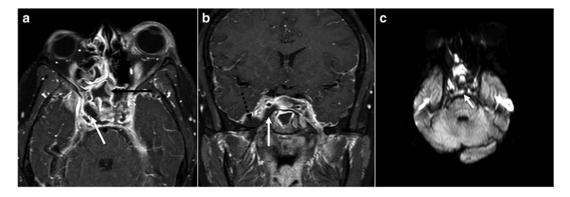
Cavernous sinus thrombosis. (a) MRI contrast axial T1 (b) MRI contrast coronal T1 (c) MR axial DWI. There is evidence of complicated sphenoiditis with right subtemporal epidural abscess and associated right cavernous sinus thrombosis. Note of decreased enhancement in the right cavernous sinus when compared to the contralateral side. Evidence of restricted diffusion is noted in the involved sphenoid sinus and cavernous sinus. *Black arrow* shows marked sphenoiditis; *white arrow* shows right cavernous sinus thrombosis with decreased enhancement; *dashed black arrow* shows peripherally enhancing epidural abscess in the right sub-temporal region with accompanying dural enhancement
